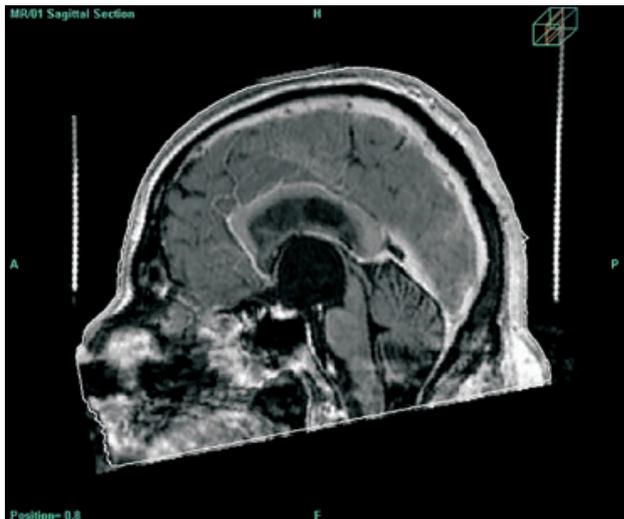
MRI image of suprasellar arachnoid cyst.
